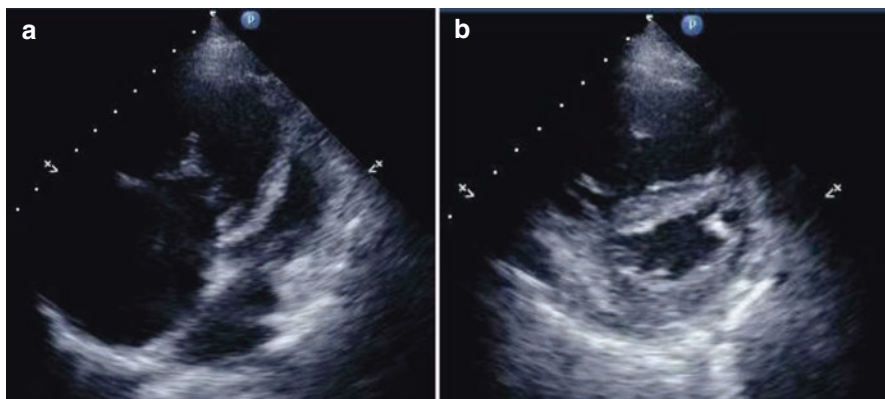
Echocardiographic images of severe PAH. Echocardiographic images of severe PAH (TRPG 83 mmHg) at 34 weeks of gestation. The patient died after Cesarean section. The right heart was severely enlarged (a), and the septum was pressed, with the LV having a D shape (b)
